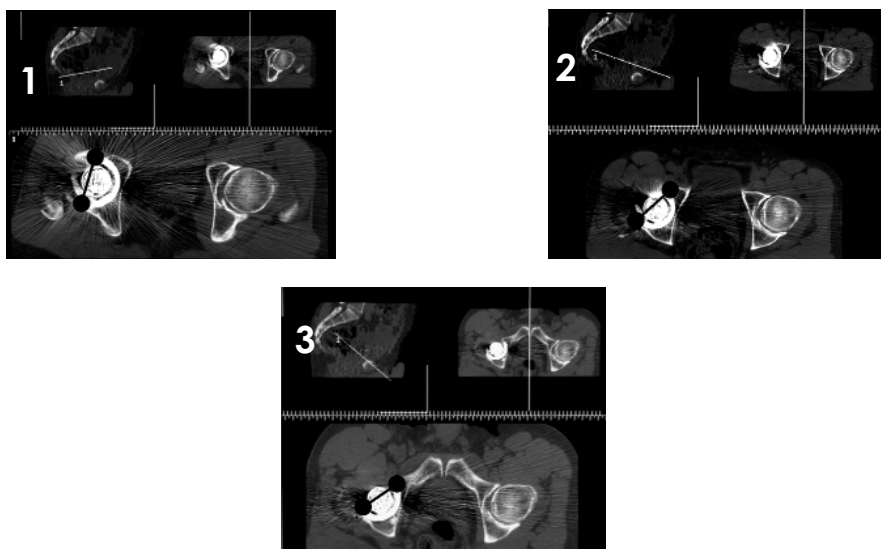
CT scan measures of « real » or « functional » acetabular anteversion from standing to sitting position. Acetabular anteversion progressively increases.
